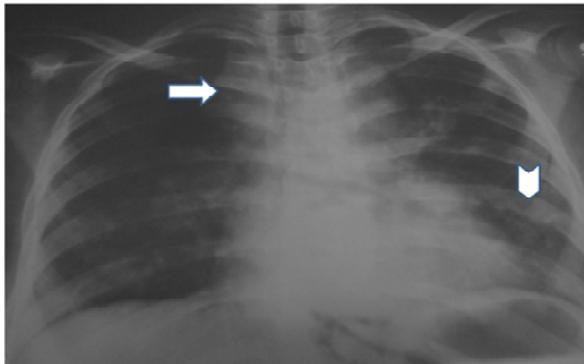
Chest radiograph (postero-anterior view) showing lobulated opacity in right and left paratracheal regions, and right hilar region, suggestive of lymphadenopathy (arrows), non-homogeneous opacity in left mid-zone suggestive of consolidation (arrows head)
